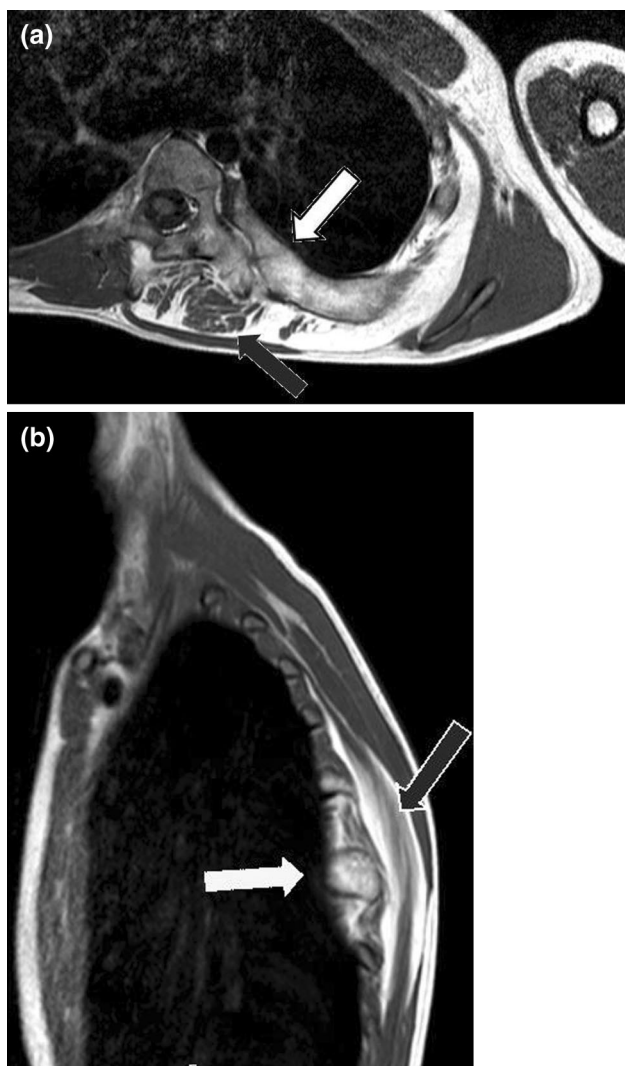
Axial (a) and sagittal (b) T1-weighted MR images showing enlargement of seventh rib and adjacent half of the thoracic vertebra (light gray arrows). Overlying is a lipomatous mass infiltrating in the paraspinal muscles (dark gray arrows). Cutaneous and subcutaneous tissues and other thoracic muscles are normal
